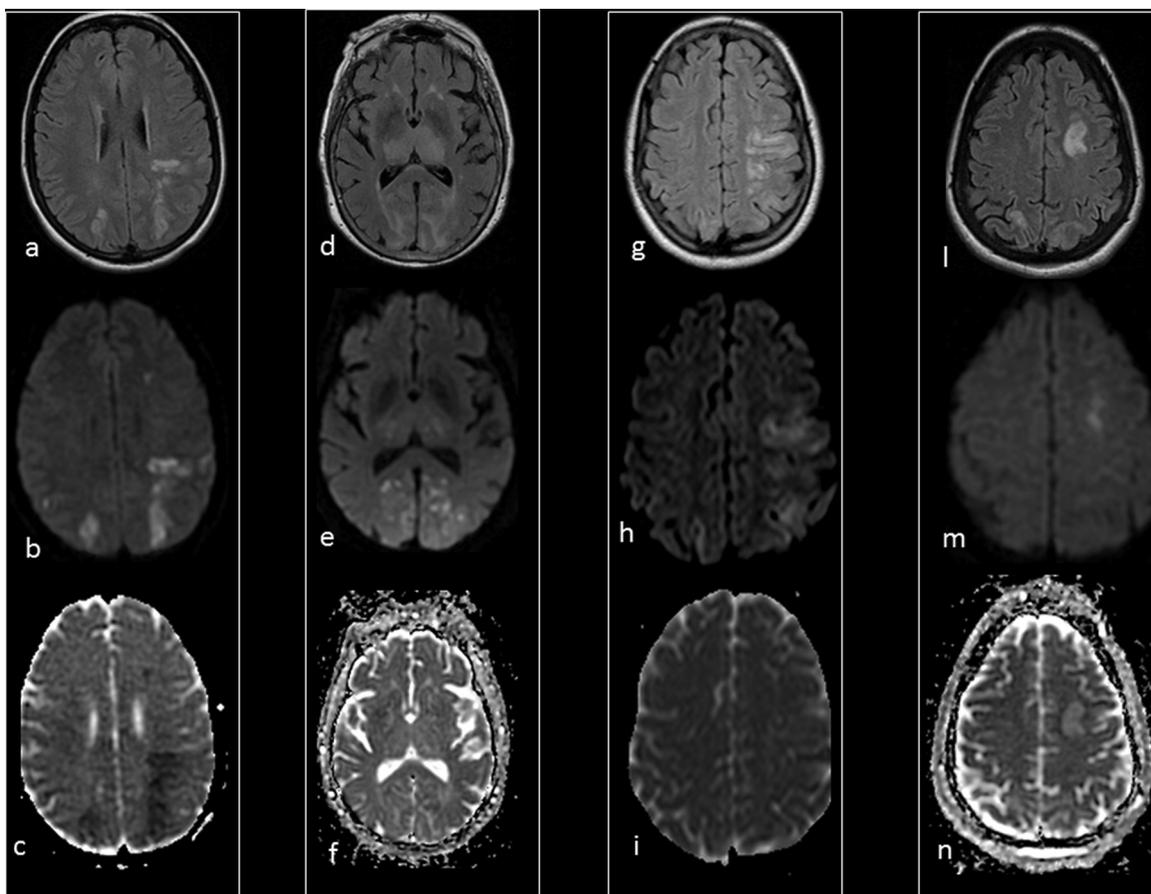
Variability of MRI signal of edema in patients with PRES.
